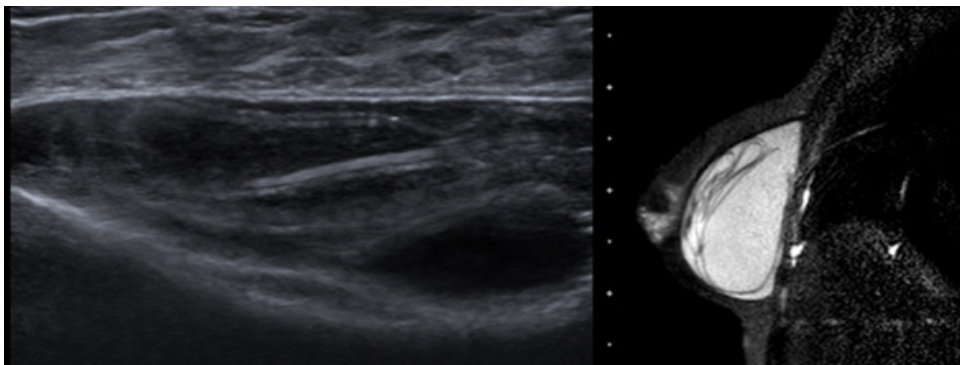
A 40-year-old woman with a history of breast augmentation 12 years ago. The ultrasound study demonstrated the presence of several curvilinear lines inside the implant (ladder sign), in correspondence with the “linguini” sign in MRI, translating the presence of intracapsular rupture.
